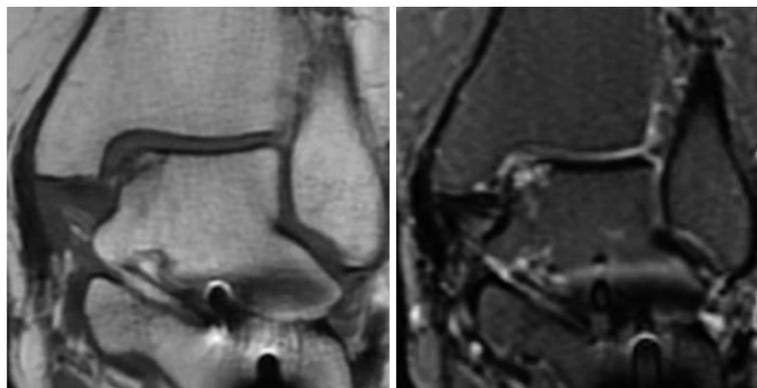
Magnetic resonance images (left-hand T1 and right-hand T2) of a patient with osteochondral lesions of the talus treated through microfractures that progressed unsatisfactorily after eight months.
